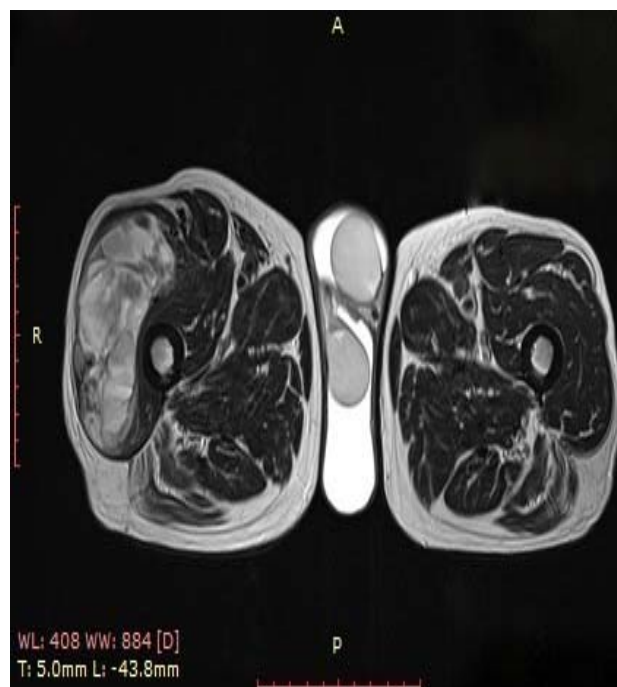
MRI TRA-T2 image (reproduced with the consent of the patient from his personal archive)
